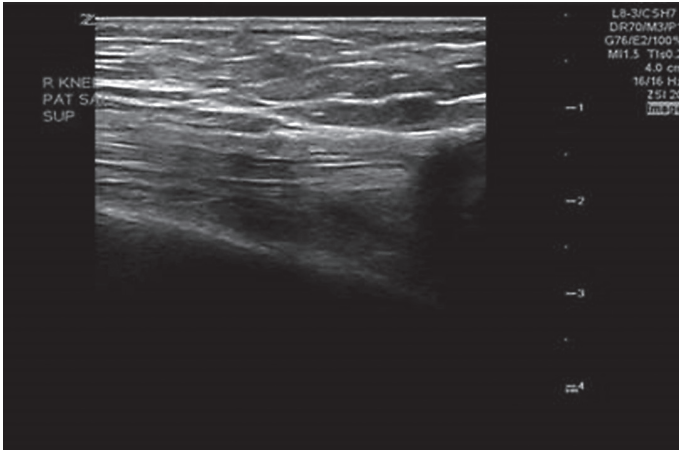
Ultrasonographic sagittal-view image using a linear L8-3 probe (Zonare Z One Pro Ultrasound System) demonstrating intact right quadriceps tendon and no knee effusion.
